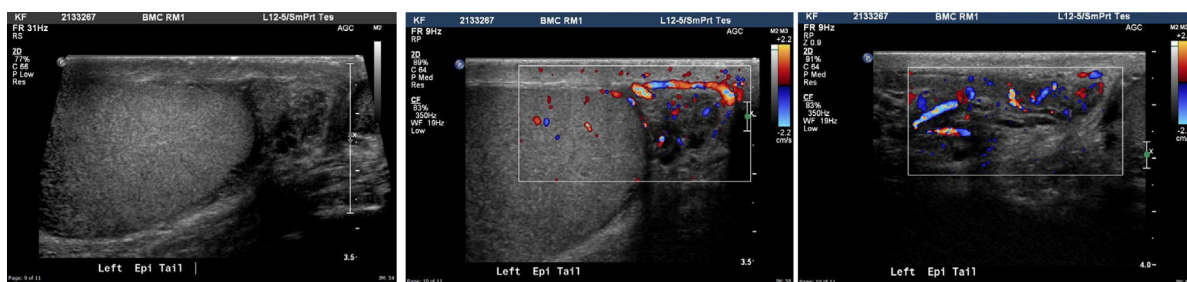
Epididymitis isolated to the epididymal tail, and normal appearance of the epididymal head and body (not shown). Enlarged, edematous epididymal tail that is heterogeneous on gray-scale analysis and demonstrates increased vascularity on color Doppler assessment. (Color version of figure is available online.)
